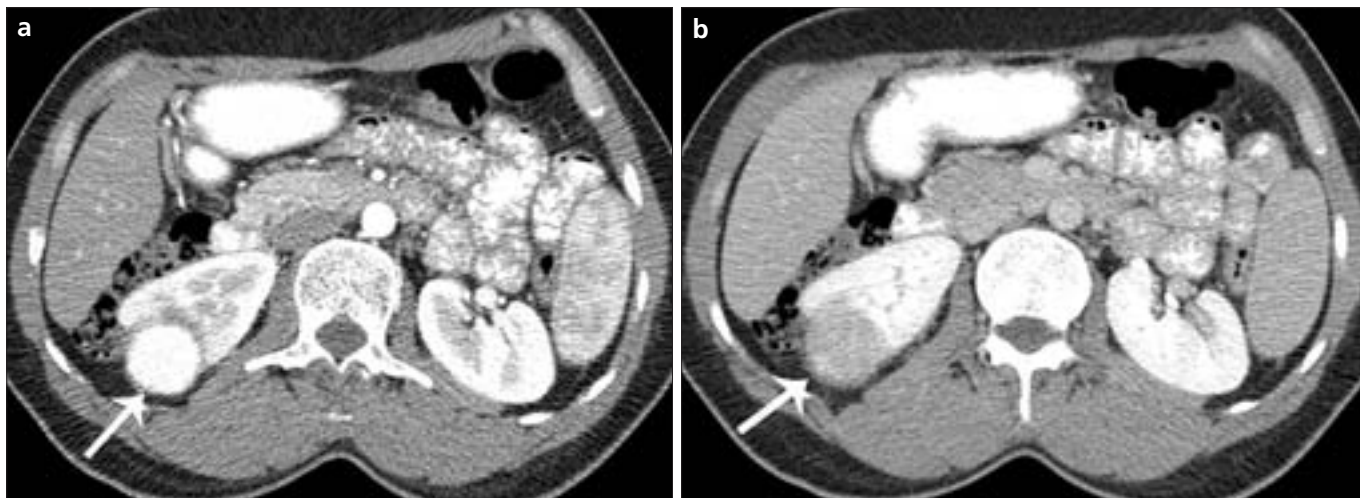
a, b. Stage T1N0M0 renal cell carcinoma in the right kidney of a 40-year-old woman. Contrast-enhanced axial CT images obtained during the corticomedullary (a) and nephrographic phases (b) show a 3.2 cm homogeneously enhancing mass (arrows) in the lower polar region of the right kidney. The patient underwent partial nephrectomy.
